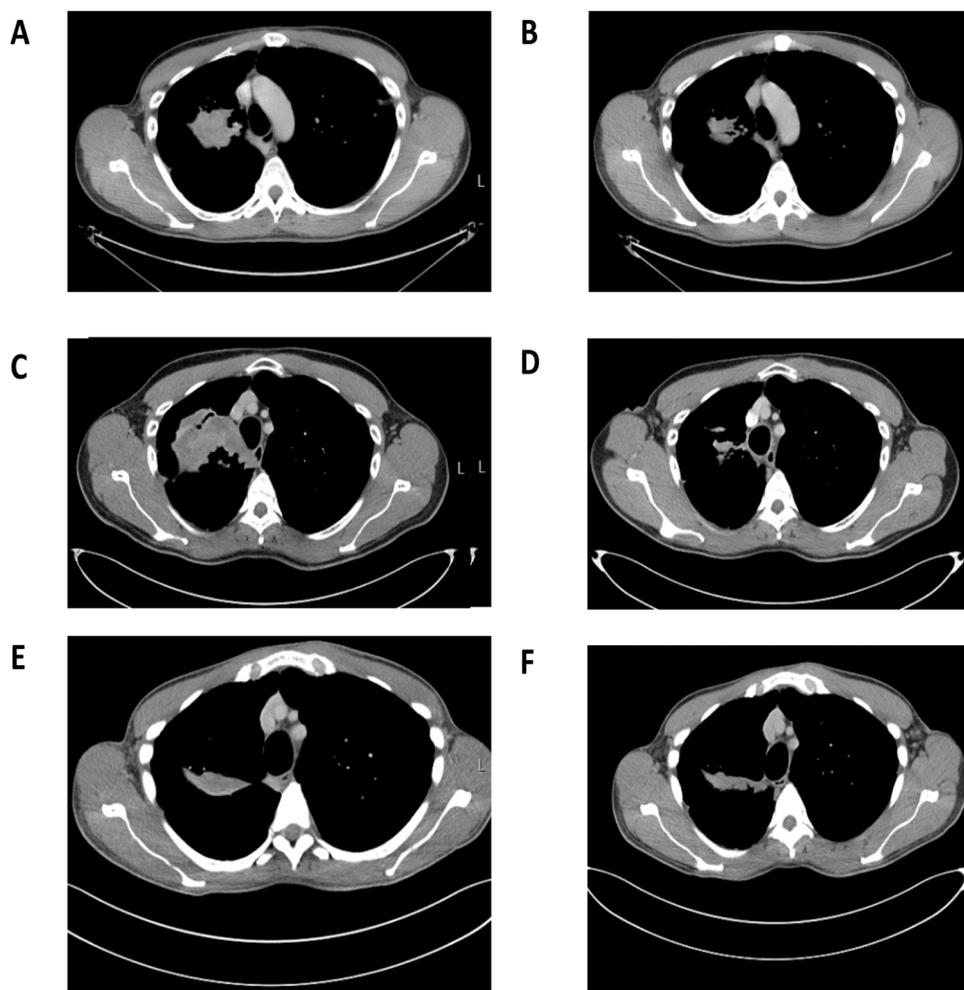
CT images showing right hilar disease and responses to ALK-targeted therapy. (a) Before and (b) after two months of crizotinib therapy; partial response before (c) and following (d) two months ceritinib; slight reduction is seen before (e) and after two months lorlatinib therapy (f).
